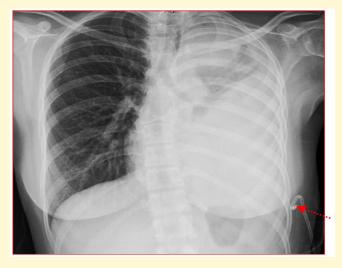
Frontal Chest Radiograph showing Pleural Pigtail Catheter not insitu.
